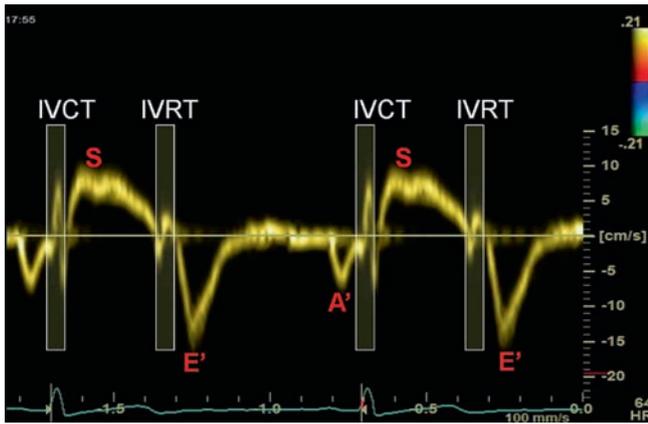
Typical pulsed Doppler tissue velocity waveform from basal septum in a young normal subject. *IVCT* isovolumic contraction time; *IVRT* isovolumic relaxation time; *S* peak systolic myocardial velocity; *E'* early diastolic myocardial velocity; *A'* regional myocardial motion due to atrial contraction
